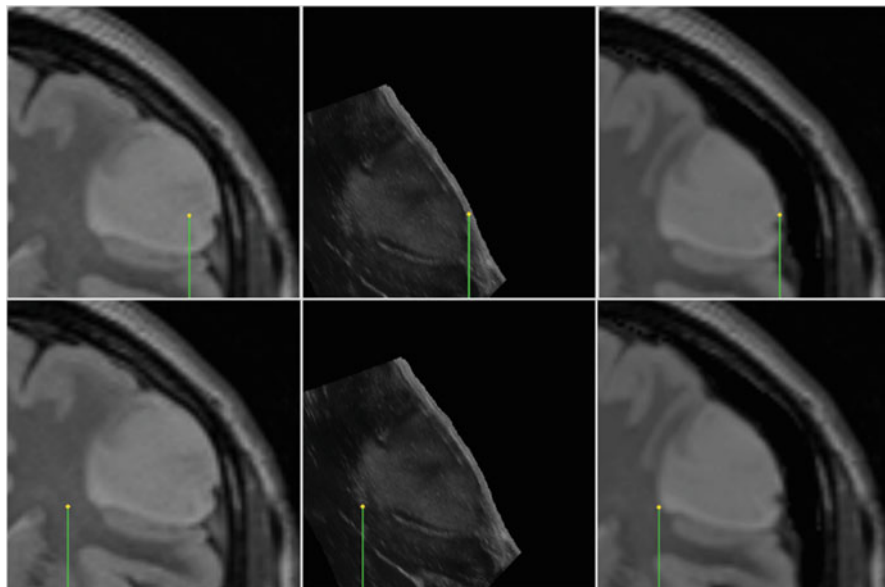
Example of pre-operative MRI, B-mode intra-operative US, and MRI updated with our method. A pointer first shows the borders of the exposed cortical surface (top row) then a deep sulcus bifurcation point (bottom row)
